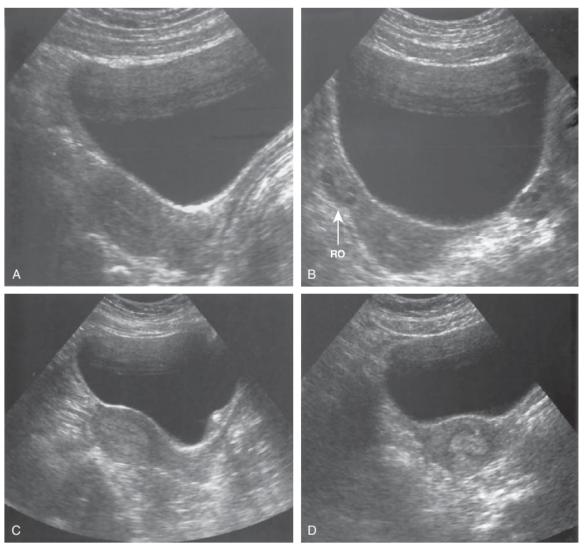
Pelvic sonography showing normal anteverted position of the uterus in sagittal views (A and C) of two separate patients. Note the polycystic (right) ovary adjacent to the uterus in the sagittal view (B) and the thickened endometrial linings in the views (C and D). (Courtesy: Dr Ketan Gundavda, Mumbai.)
